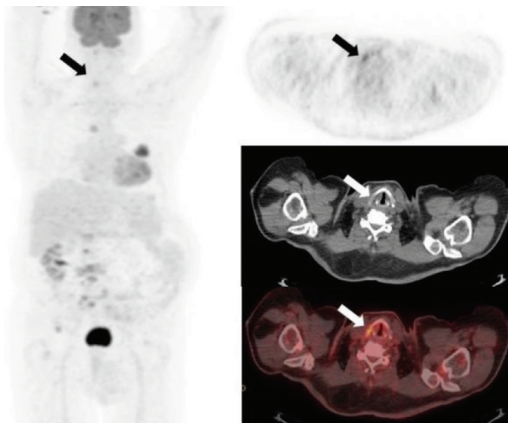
FDG PET/CT imaging
